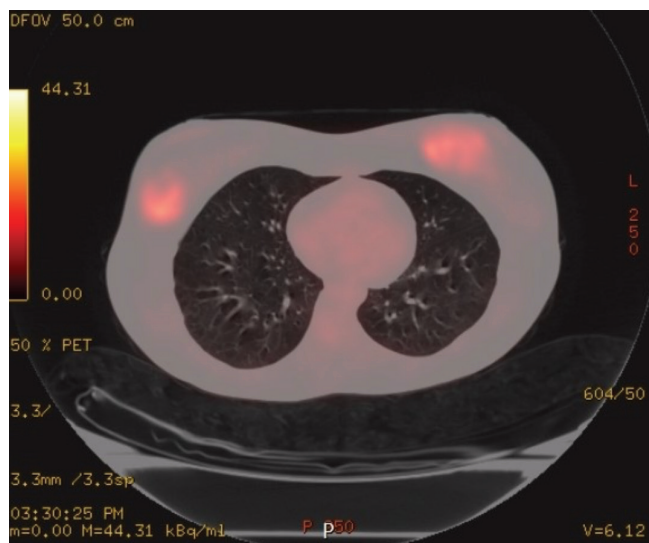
Axial paranchimal fused PET/CT image showing massive lesions of 4 cm in the right breast and 5 cm and 1.5 cm in the left breast (SUV_{max} = 9) and 1 cm (SUV_{max} = 3.7) increase in metabolism areas in both axilla
